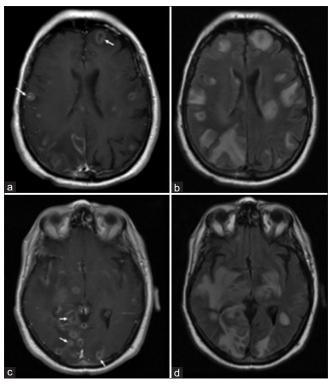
Postcontrast T1-weighted (a, c) and FLAIR (b, d) axial images of the brain showing multiple ring-enhancing lesions, some of which demonstrated an eccentric target sign (arrows) with associated surrounding moderate vasogenic edema.
